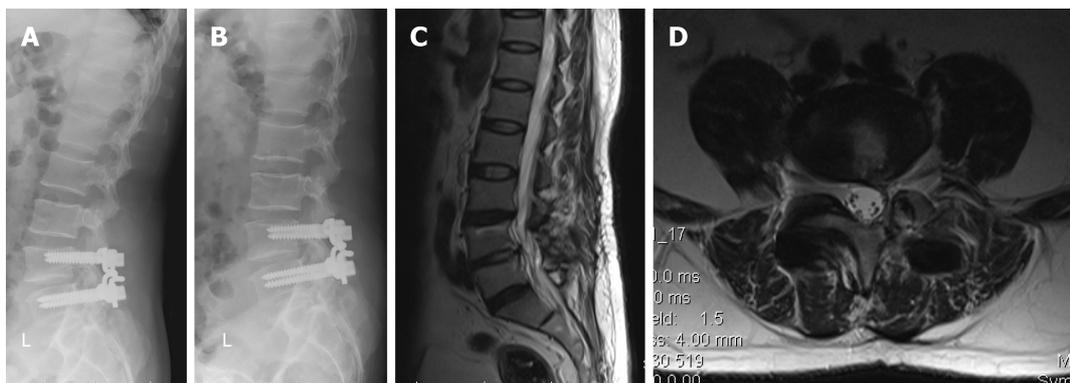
Postoperative imaging assessment. A and B: Postoperative extension-flexion radiographs revealed that partial movement was reserved in the implanted level; C and D: Magnetic resonance imaging demonstrated disc rehydration within L4-5 at the 2-yr follow-up.
